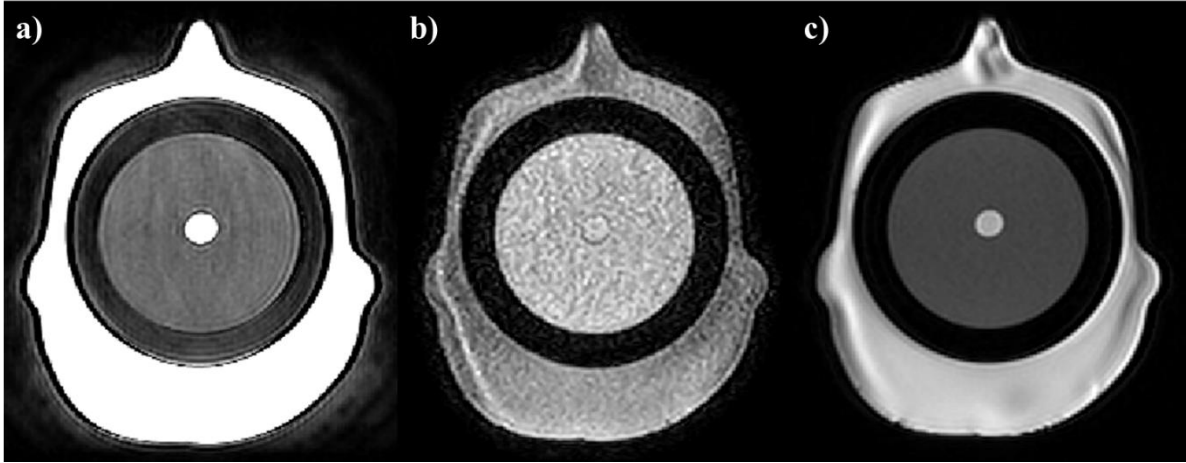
a) T2-weighted MRI, b) T1-weighted T1CE MRI, and c) T1-weighted no CE MRI.
